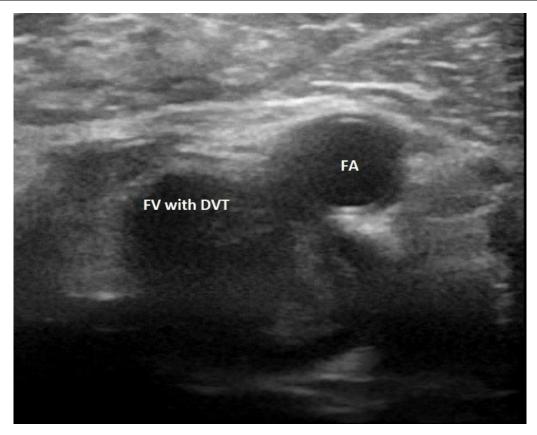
Ultrasound image showing the left femoral vein (FV) containing thrombosis and the femoral artery (FA).
